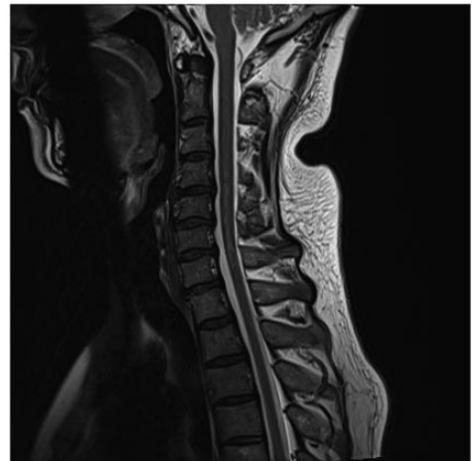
Representative sagittal T2-weighted magnetic resonance image of the cervical spine obtained at 3 months after the onset of myelitis symptoms, showing a high T2 signal in C4 to C7 segments of the spinal cord.
